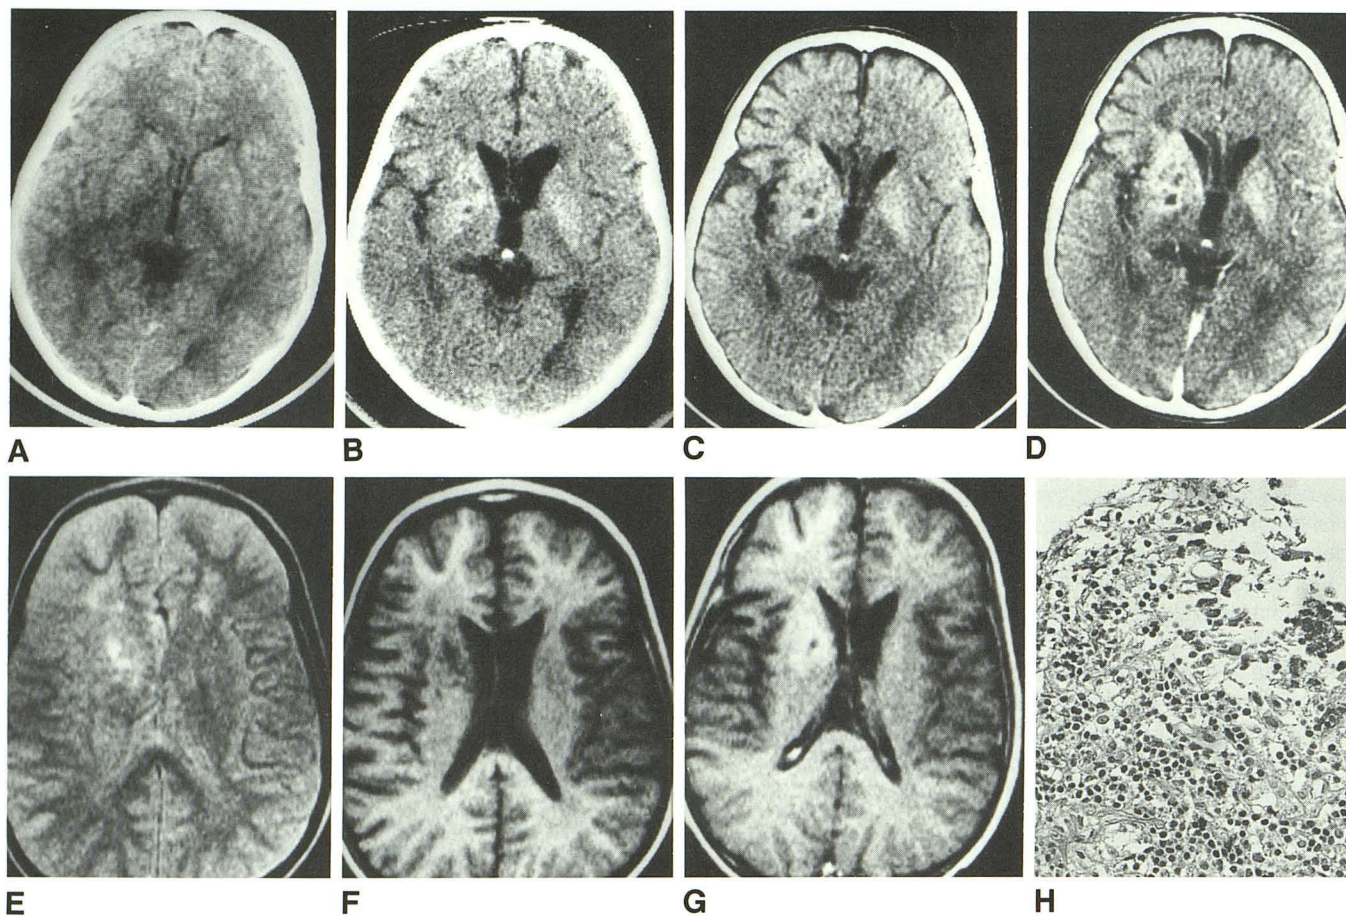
A, 6-year-old boy. Initial CT shows no abnormality.
